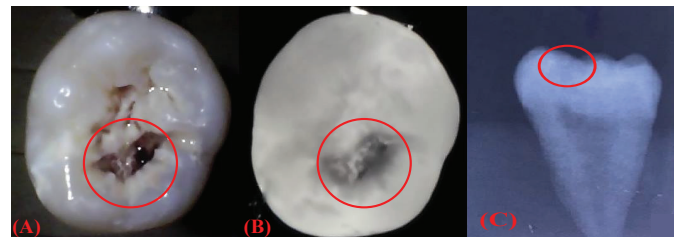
Sample 4 under visible light (A), NIR light (B), and X-ray (C).
